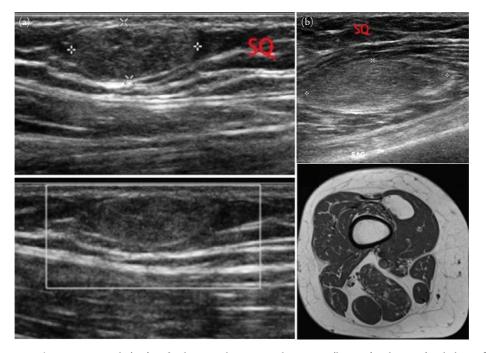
(a) Subcutaneous lipoma. Grayscale (top) and color Doppler sonographic images (bottom) in longitudinal plane of the volar forearm show a subcutaneous (SQ) soft tissue mass. The mass is hyperechoic compared to adjacent subcutaneous fat. Some of the lesion borders are not well seen and blend imperceptibly with the subcutaneous fat. No flow is seen on Doppler. (b) Intramuscular lipoma. Grayscale longitudinal ultrasound image of the thigh (top) shows an oval intramuscular soft tissue mass in the vastus medialis. The mass is heterogeneous in echotexture without internal flow on Doppler (not shown). This lipoma is not in the subcutaneous (SQ) soft tissues. Companion axial T1W magnetic resonance image (bottom) shows a circumscribed fat-signal intensity mass typical for a low-grade intramuscular lipomatous lesion such as a simple lipoma.
